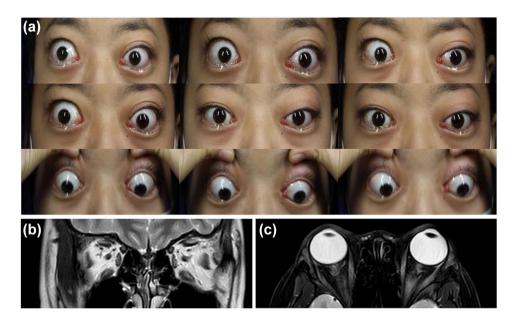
Nine-directional ocular photographs and orbital MRI before treatment. (a) The nine-directional ocular photographs revealed pronounced proptosis and bilateral restricted eye motility of inward, outward, and upward. (b, c) Orbital MRI revealed thickening extraocular muscles and abnormally increased signal intensity of extraocular muscles on coronal (b) and transverse (c) T2-weighted imaging. MRI, magnetic resonance imaging.
